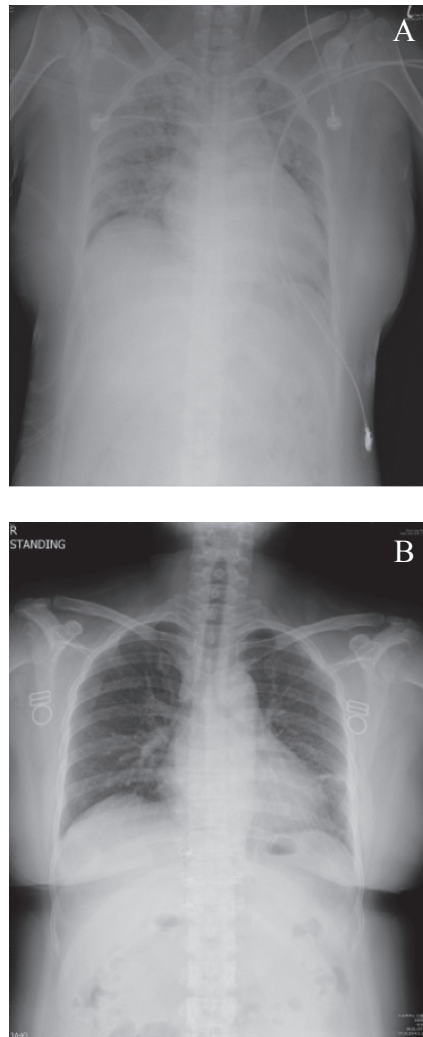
Follow-up chest x-rays on the second day (A) and the seventh day (B) after admission.
